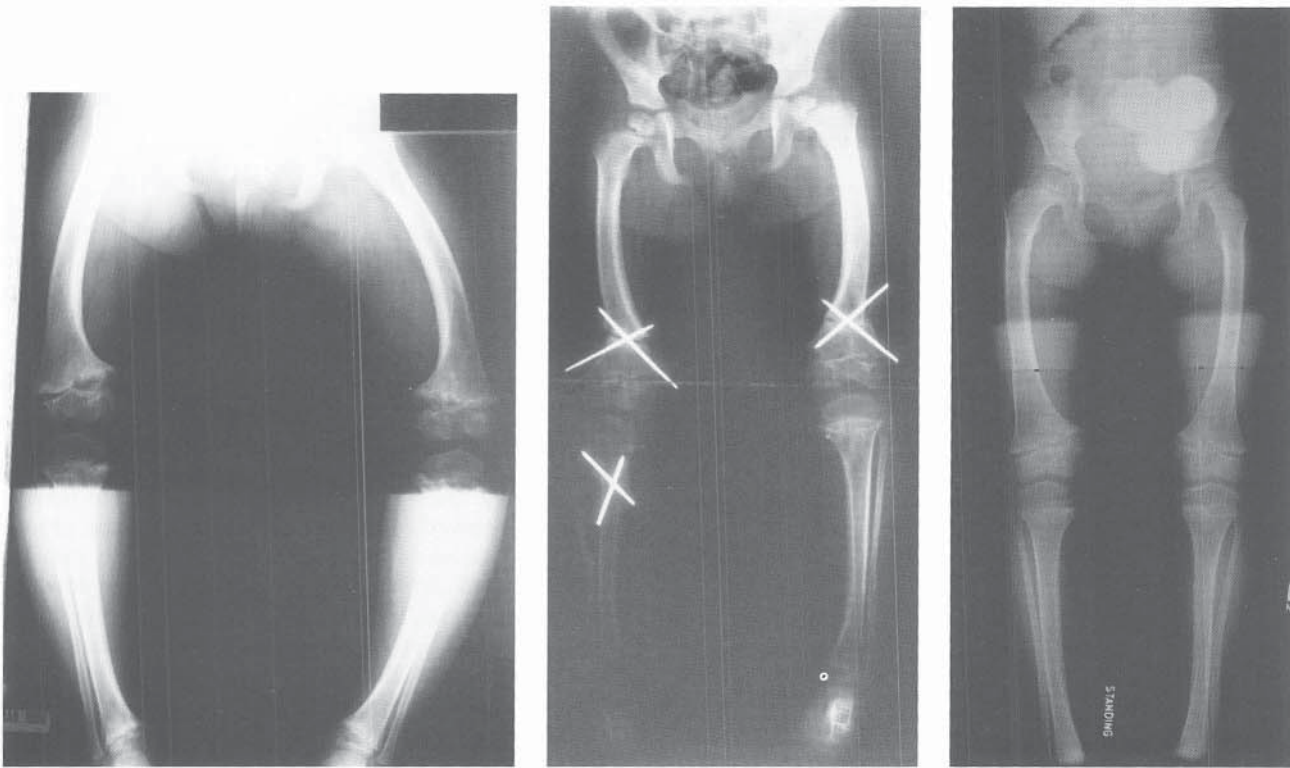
AP radiographs of the child age 4 years 9 months with Schmid's metaphyseal chondrodysplasia from Fig. 29-55 before, immediately after, and 2 years after realignment osteotomies.
